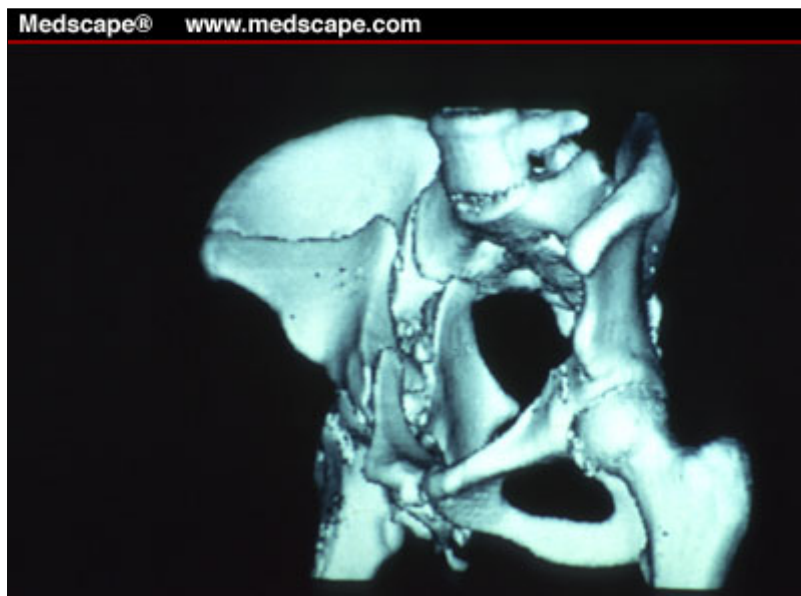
3-D CT scan of a both-column acetabular fracture; iliac oblique view.
